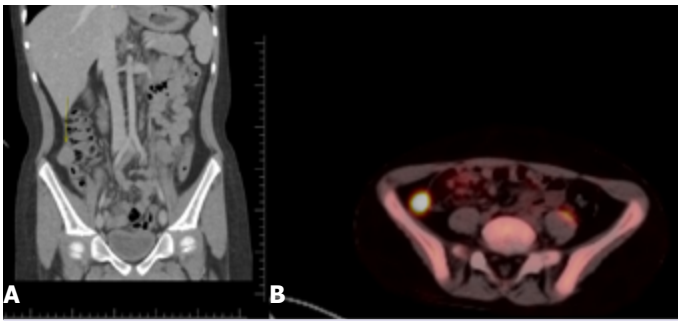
(A) A mass compatible with residual lymphoma localized in the ileocecal region (white arrow). (B) Radioactive activity involvement in the residual mass (PET CT).
